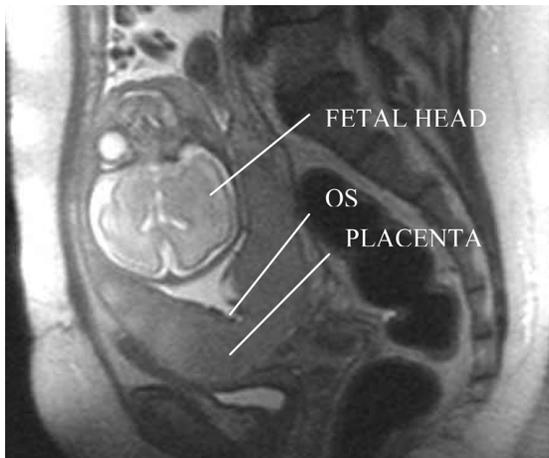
MRI of a grade IV placenta previa (completely covering the internal os)
